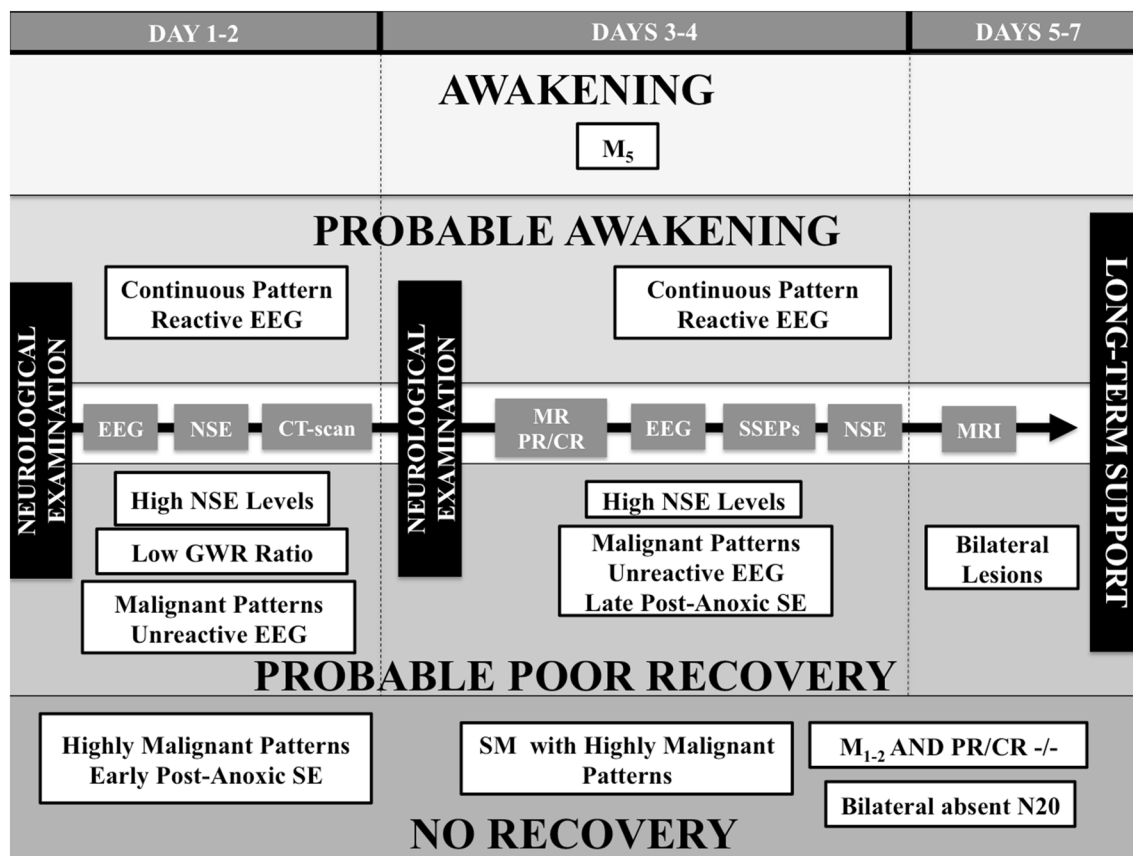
Multimodal approach for prognostication of neurological outcome after cardiac arrest. *EEG* electroencephalogram, *NSE* neuron-specific enolase, *CT* computed tomography, *MR* motor response, *CR* corneal reflexes, *PR* pupillary reflexes, *GWR* grey- to
